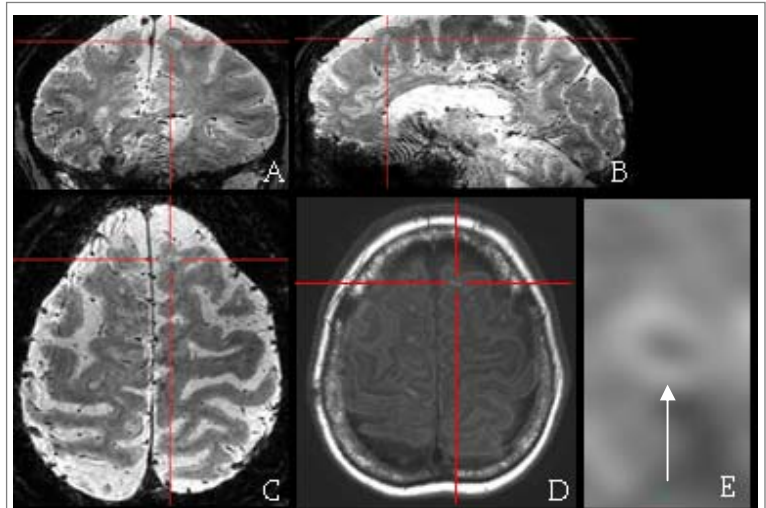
T_2^* images of peripheral WM lesion in A) coronal, B) sagittal and C) axial planes. D) shows the corresponding slice in the FLAIR image and E) shows a magnified version of the lesion identified in T_2^* image.
